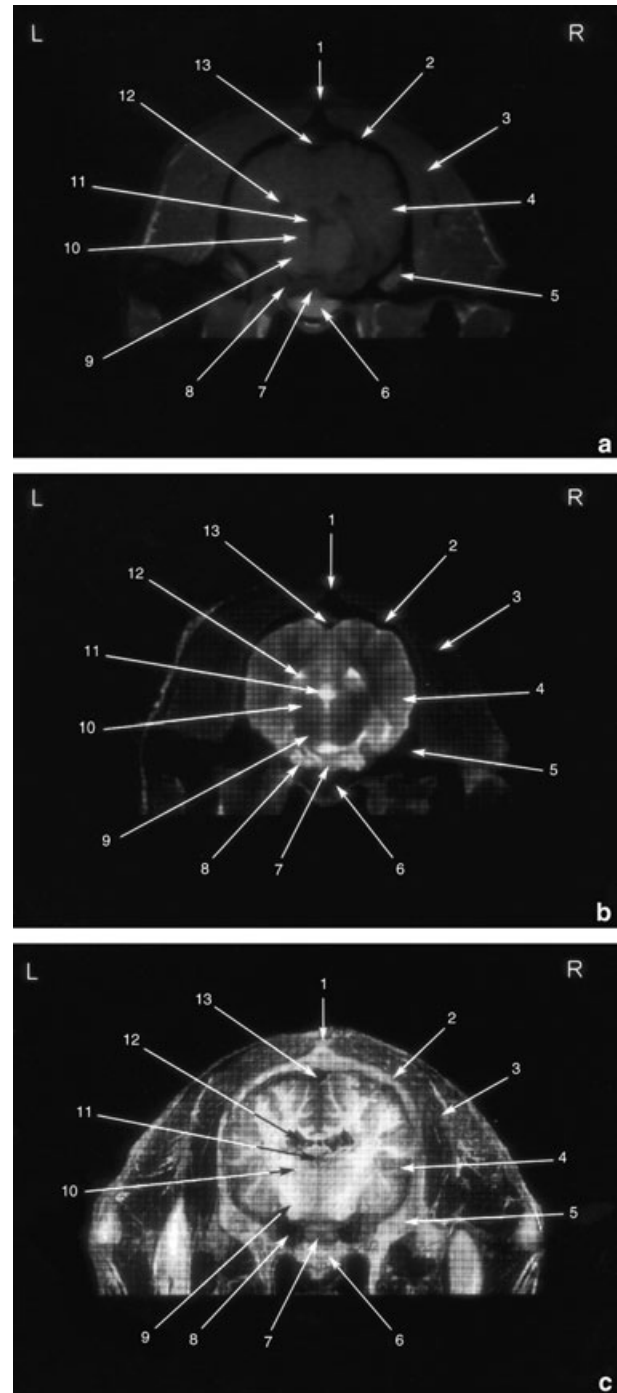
(a) T1-weighted transverse MR image, (b) T2-weighted transverse MR image, and (c) gross sections at the level of thalamus and third ventricle. 1, External sagittal crest; 2, parietal bone; 3, temporal muscle; 4, cerebral hemisphere: cerebral cortex; 5, squamous part of temporal bone; 6, body of basisphenoid bone; 7, pituitary gland; 8, cavernous sinus and maxillary, trochlear, abducent and ophthalmic nerves; 9, hypothalamus; 10, thalamus; 11, third ventricle; 12, lateral ventricle; 13, dorsal sagittal sinus.
